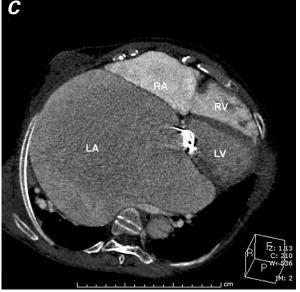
Chest computed tomograms. A) Coronal view shows marked splaying of the carina, caused by severe left atrial (LA) enlargement. B) Sagittal view shows compression and partial atelectasis of the lung's right lower lobe from the enlarged LA, and partial compression of the esophagus against the midthoracic spine. C) Three-dimensional reconstruction reveals the LA's position within the thoracic cavity and its size in comparison with the other cardiac chambers.
